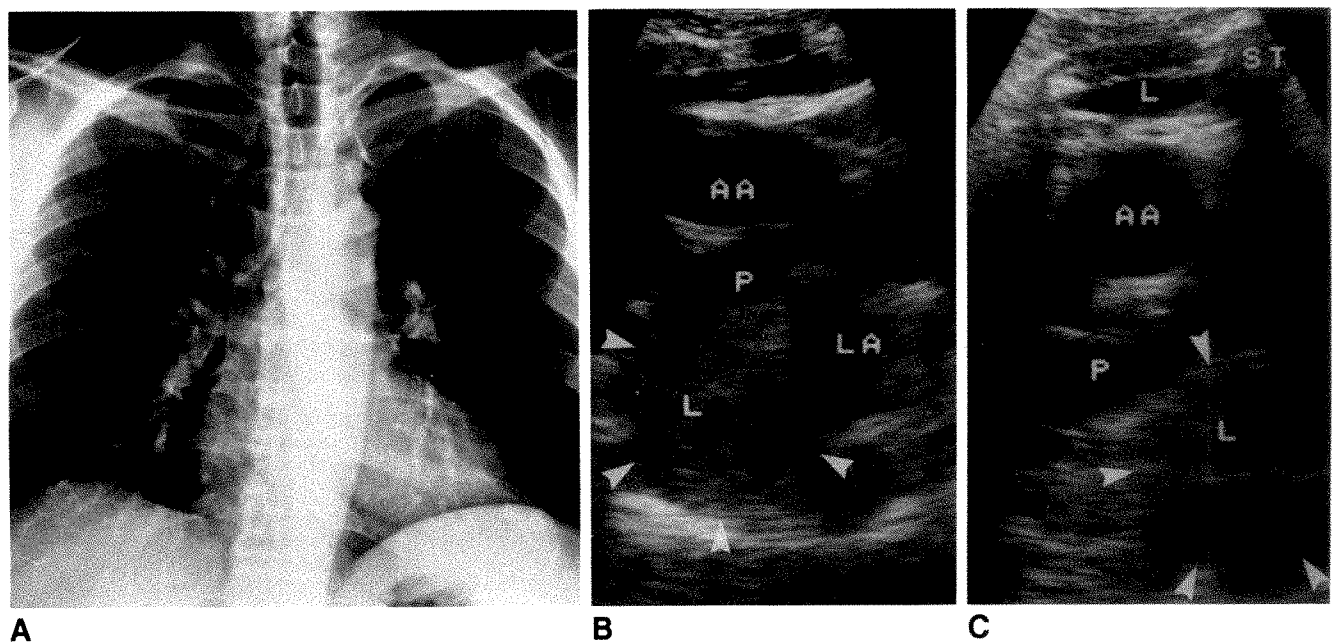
Initial findings on plain radiographs and sonograms in 54-year-old man with non-Hodgkin lymphoma.
